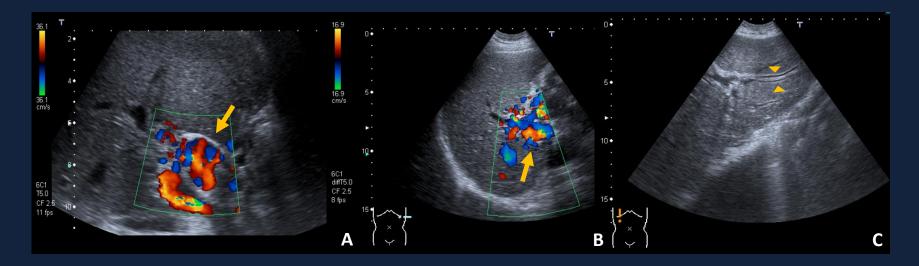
62-year old male patient with portal cavernoma. (A) and (B) Doppler-US images demonstrating portal cavernoma transformation (arrow) due to extra-hepatic portal vein obstruction. (C) US image show intra-hepatic bile duct dilatation (arrowhead) due to extrinsic compression from paracholedocal veins of the portal cavernoma.
